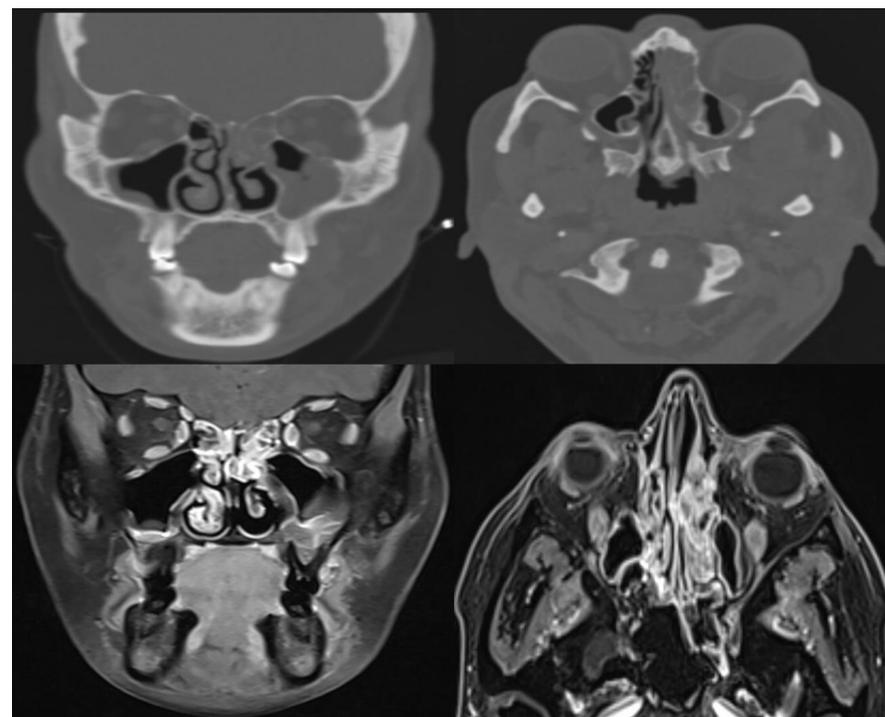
Pre-Operative CT Sinus and MRI Face Scans
